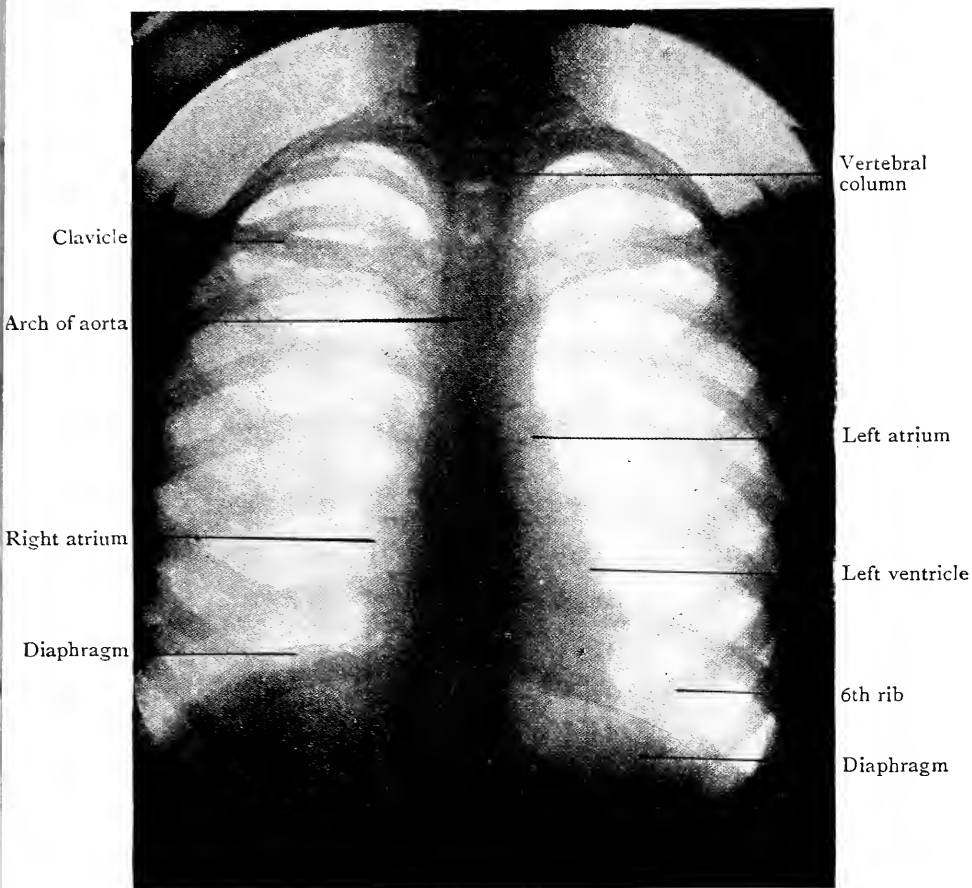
Radiograph of Thorax viewed from the front.
